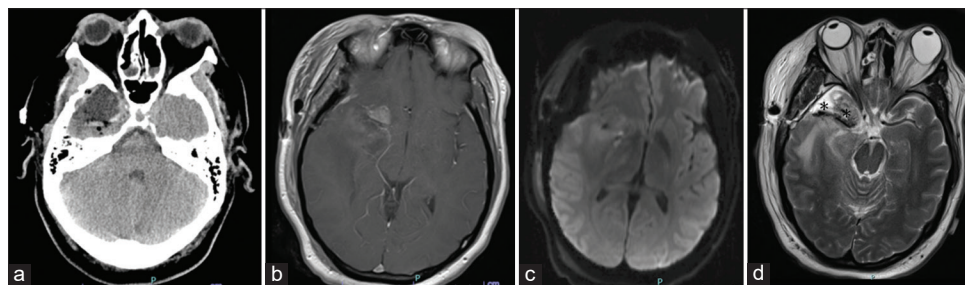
(a) Postoperative CT with minimal hemorrhage in the posterior aspect of the resection cavity. (b) The T1 magnetic resonance imaging (MRI) with contrast respectively, with small amount of residual tumor anterosuperiorly and medially, with small amount of hemorrhage within the resection cavity and no evidence of hemorrhage within the basal cisterns. (c) Diffusion-weighted imaging without any evidence of infarct. (d) A T2 MRI with hypointensities along exposed middle cerebral artery (asterisks), representing Gliadel wafer lining the vessel and cavity.
